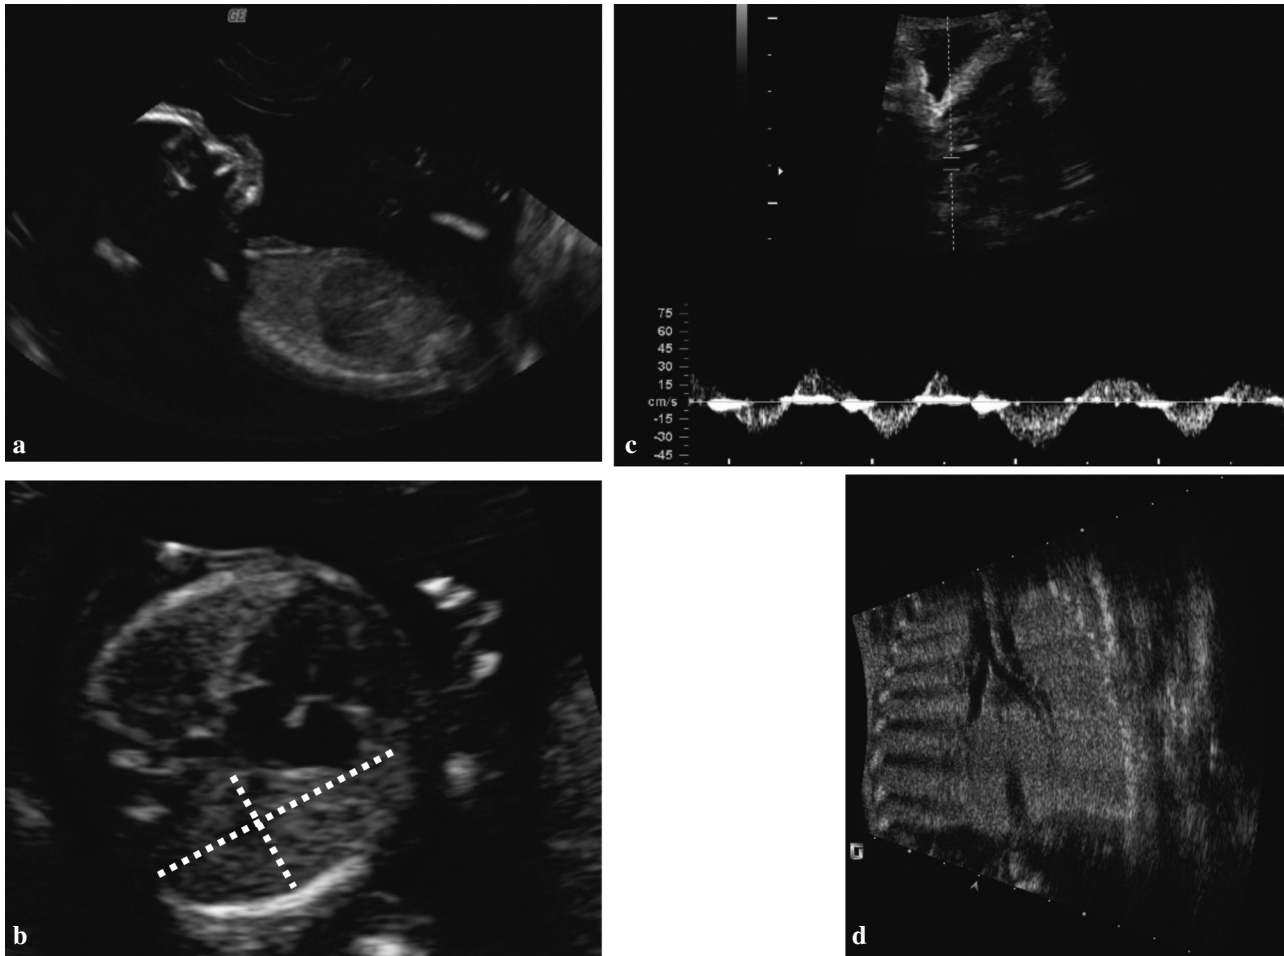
Normal lungs, airways and diaphragm. (a) Prenatal ultrasound of the normal diaphragm at 15 weeks of gestation in a longitudinal section. (b) Cross-section through the thorax is taken in the four chamber view and one of the lungs is measured as would be done for cases with CDH. (c) Using Doppler, movement of fluid in the upper trachea can be demonstrated. (d) upper airways “bronchogram”, which can be easily seen in a fetus with laryngeal atresia, causing obstruction to lung fluid (from Oepkes *et al.*, 2003; reprinted with permission of ISUOG and Wileys).
